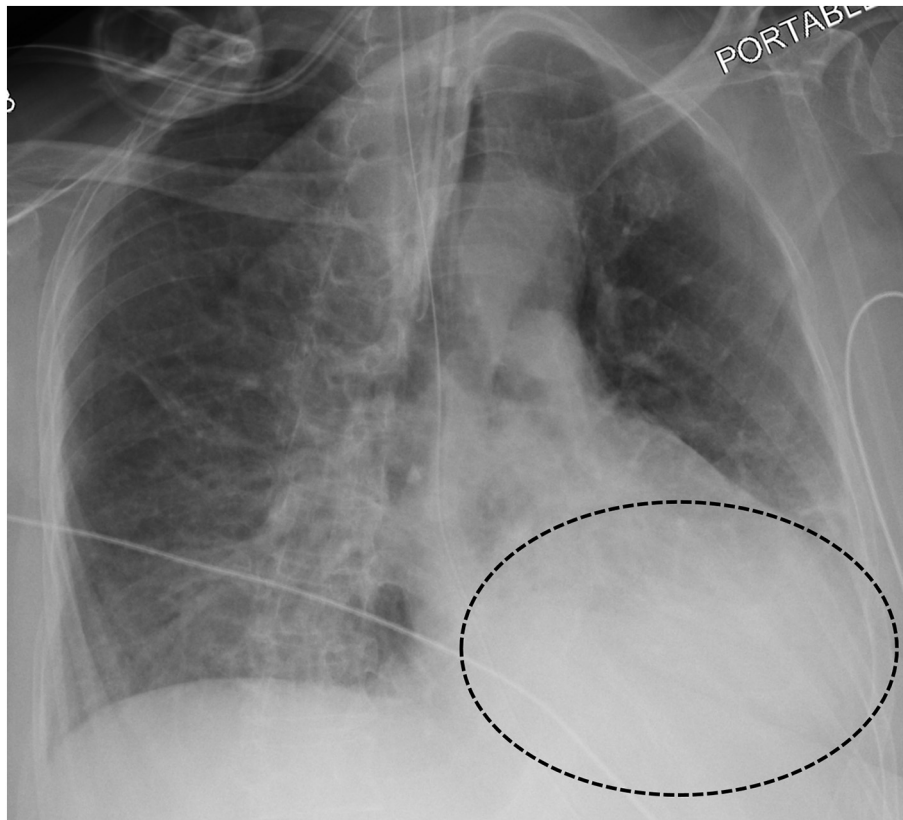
Frontal chest radiograph demonstrating a retrocardiac parenchymal opacity (circle) obscuring the diaphragmatic border.
